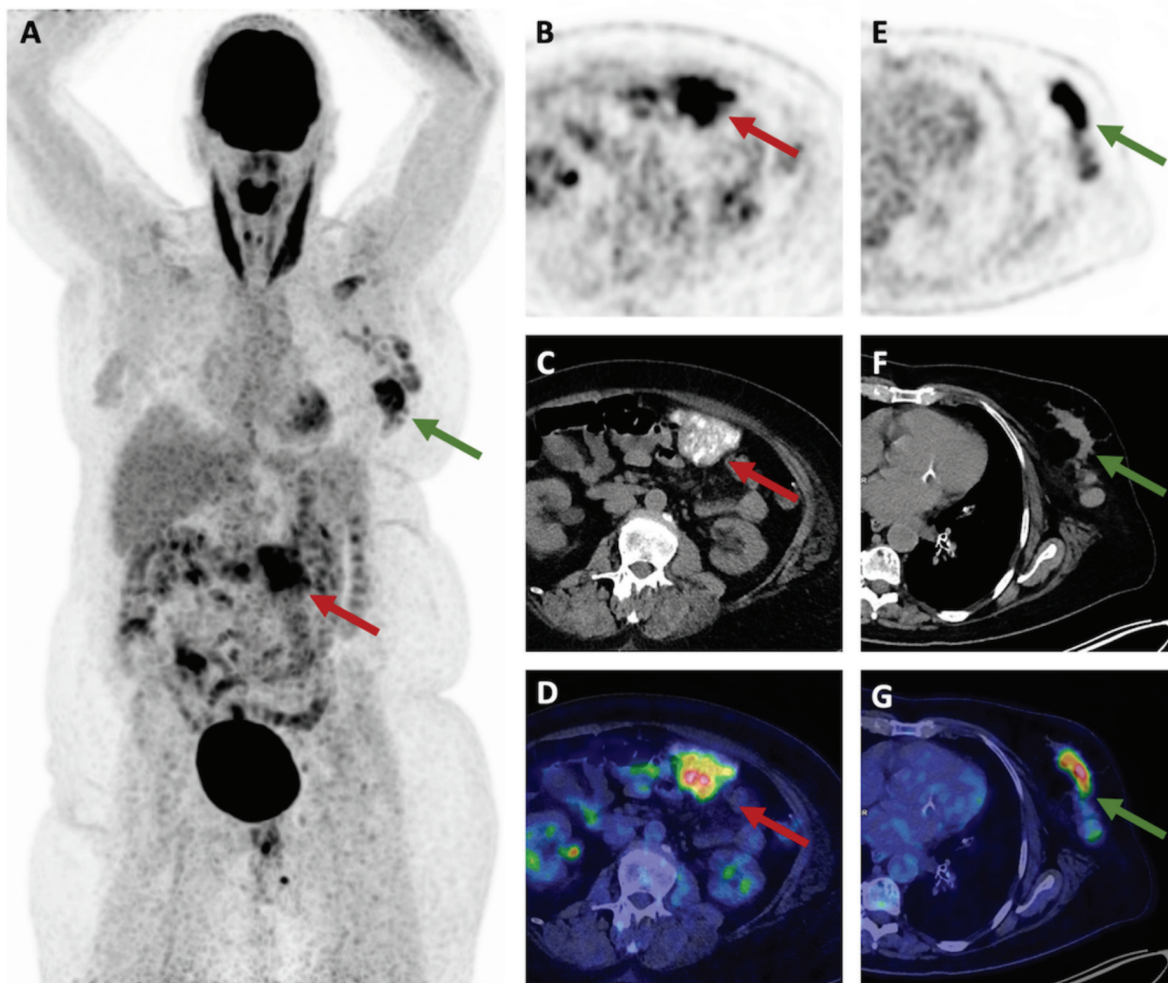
A 63-year-old woman underwent ^{18}F -fluorodeoxyglucose (^{18}F -FDG) positron emission tomography/computed tomography (PET/CT) for initial extension work-up of a lobular breast carcinoma. Maximum intensity projection (A), axial attenuation-corrected PET (E), transaxial CT (F), and fused PET/CT (G) images showing intense tracer uptake in the breast lesion (green arrows) associated with homolateral axillary lymph node involvement. Additionally, maximum intensity projection (A), axial attenuation-corrected PET (B), transaxial CT (C), and fused PET/CT (D) images revealed increased ^{18}F -FDG uptake by a large heavily calcified omental soft-tissue mass (red arrows), which was associated with less-FDG-avid disseminated calcified peritoneal lesions. Increased ^{18}F -FDG uptake in the calcified lesion was also observed in non-attenuation corrected images. No ovarian mass was detected.
